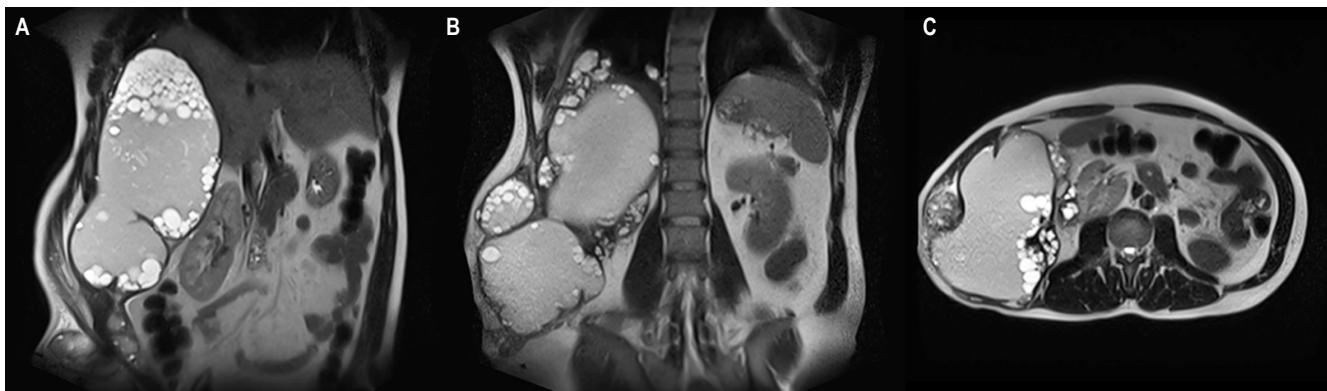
Follow-up abdominal MRI. A. Coronal view showing extensive hepatic involvement with multiple hydatid cysts. B and C. Coronal and axial views confirming hydatid cyst infiltration into the abdominal wall. Images property of the authors.
